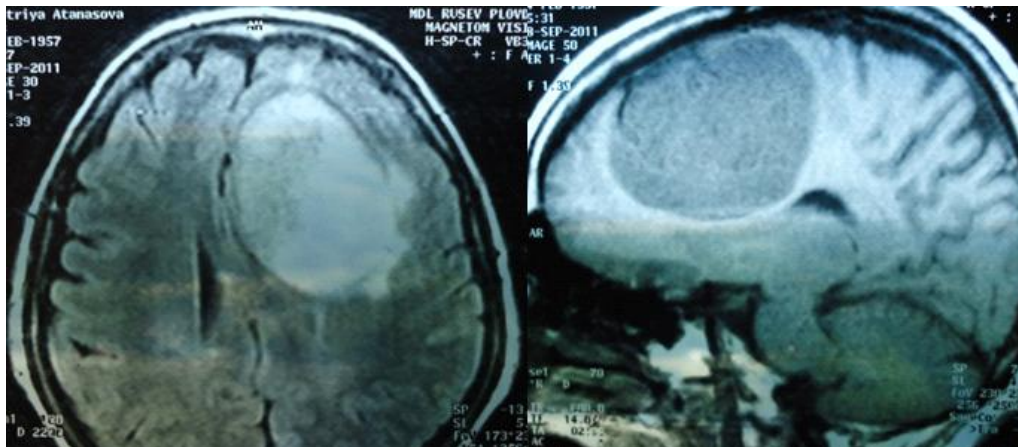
MRI images (axial and sagittal projection) of convexity meningioma
